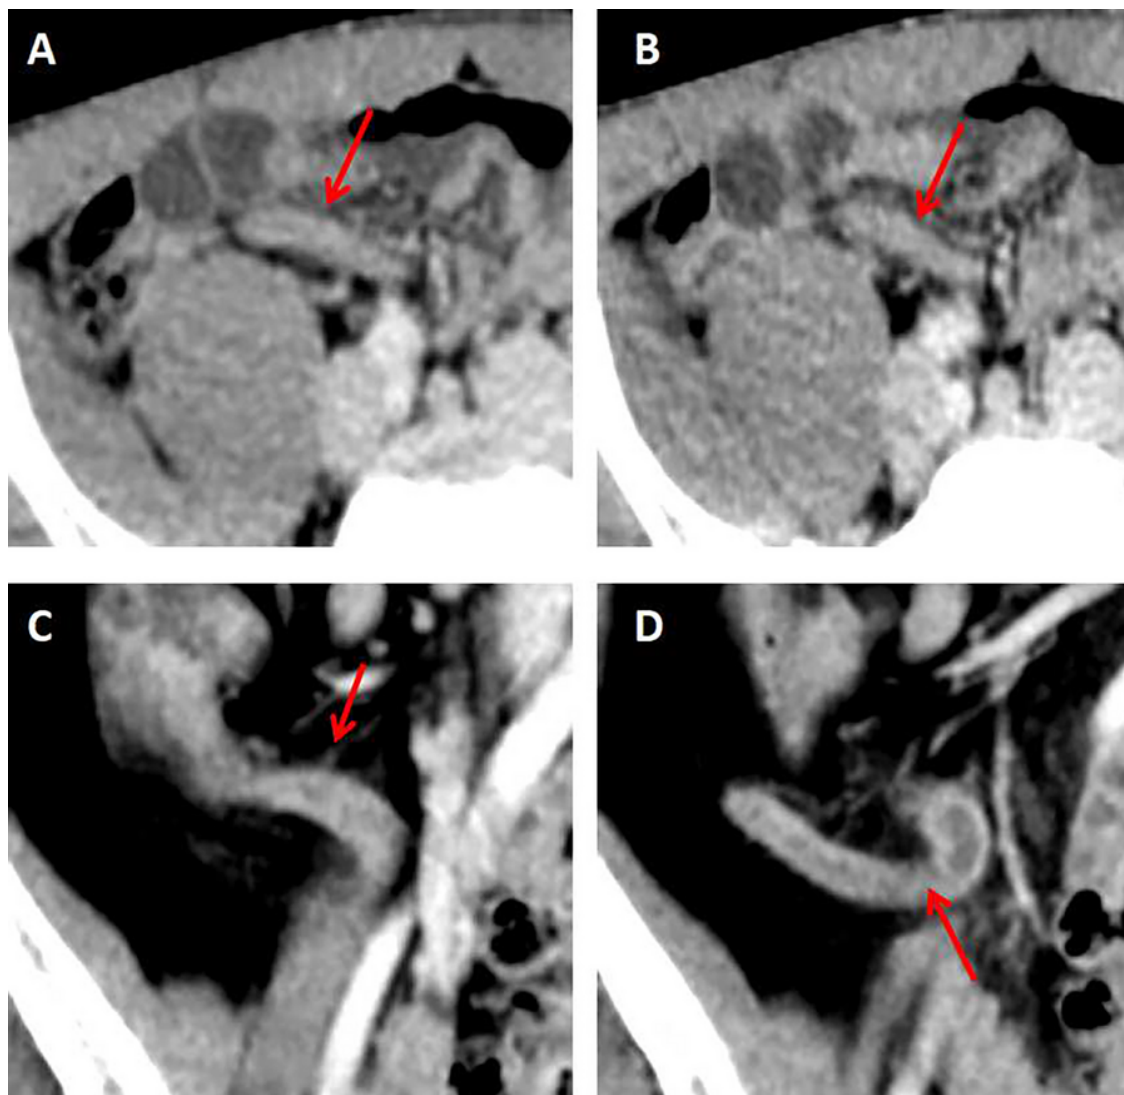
Image appearance of an erected appendix: A and B, a 21-year-old male patient with appendicitis. Post contrast computed tomography (CT) on axial view showed an erected "I shape" appendix (red arrows). The appendix diameter was 6.6 mm. Note also the appendix had abnormal wall enhancement and filled with fluid; C and D, a 62-year-old male patient with appendicitis. Post contrast CT on coronal view showed an erected "C shape" appendix (red arrows) with abnormal wall enhancement and intraluminal fluid. Appendix diameter was 8 mm.
